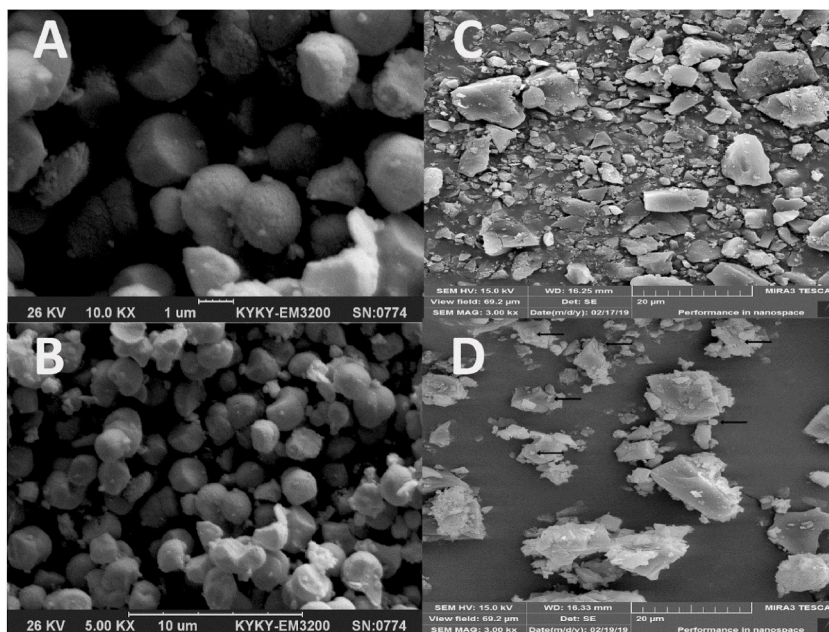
SEM images of (A and B) salbutamol sulfate dry powder inhalers prepared by ultrasonic atomizer, (C) Lactohale®, (D) engineered salbutamol sulfate mixed with Lactohale®. The arrows indicate salbutamol particles attached to the Lactohale®.
